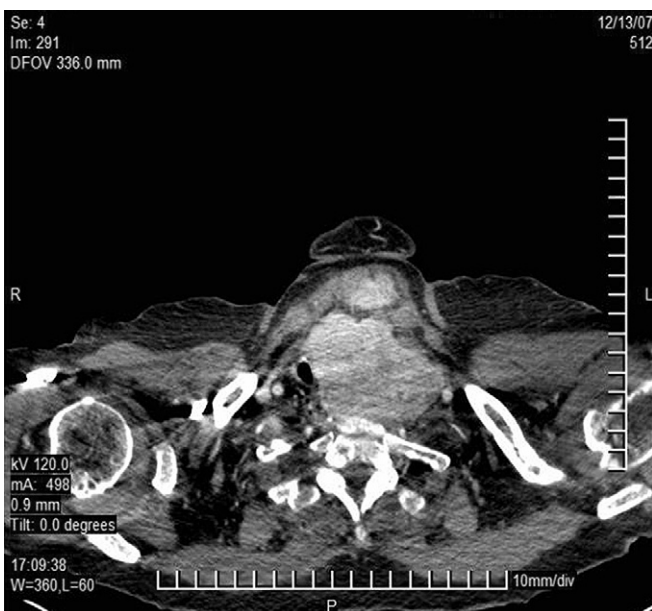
Computed tomography scan. There is mediastinum involvement with tracheal stenosis and esophageal deviation due to the retrosternal goiter.
